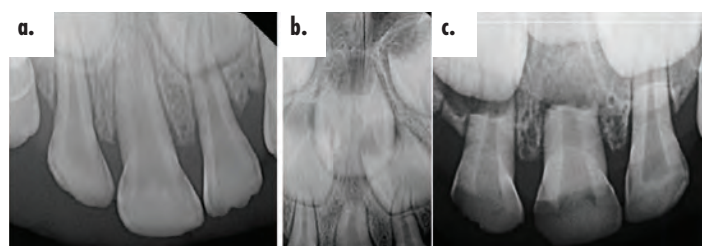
Sequential periapical radiographic images of patient in Case 2. Patient's periapical radiograph at age 3 displays characteristic SMMCI morphology and position within primary dental arch (a). By age 4, permanent SMMCI exhibiting same morphology can be identified in periapical radiograph (b). Periapical radiograph obtained at age 7 exhibits root resorption of primary dentition in addition to eruption of permanent lateral incisors and permanent SMMCI (c).
